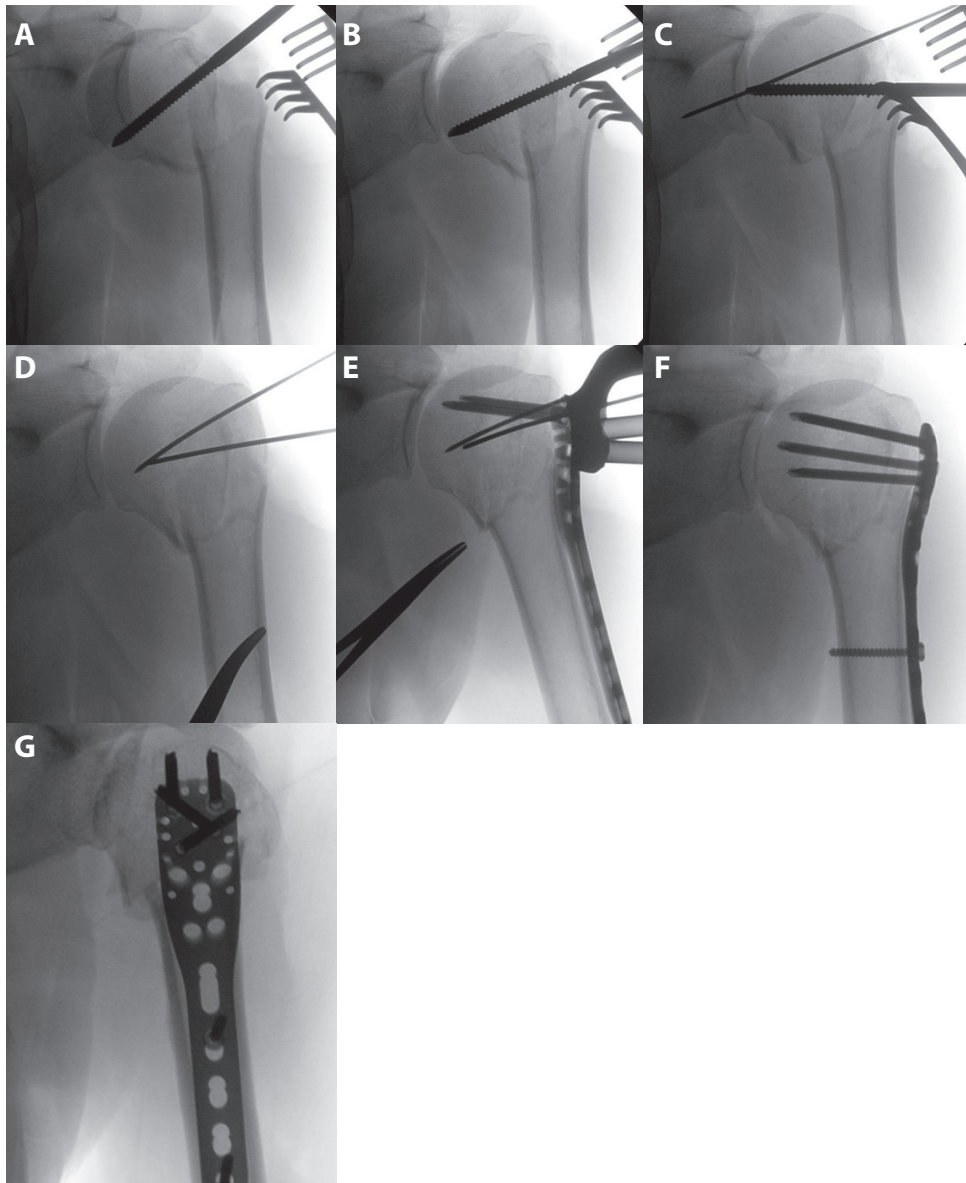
Intraoperative images of the osteosynthesis with a PHILOS plate through an anterolateral deltoid split approach. 2a insertion of a Schanz-screw in the humeral head. 2b reduction of the humeral head in the glenoid fossa using the Schanz-screw with T-handle. 2c temporary retention of the humeral head with a transfixation on to the glenoid using a K-wire. 2d reconstruction of the humeral head and temporary fixation with K-wires. 2e insertion of the PHILOS plate using the aiming device with proximal fixation with 2 angular stable screws. 2f and 2g final x-rays after PHILOS plate fixation with proximally 4 angular stable screws and distally 2 conventional screws in AP and lateral view fixation
